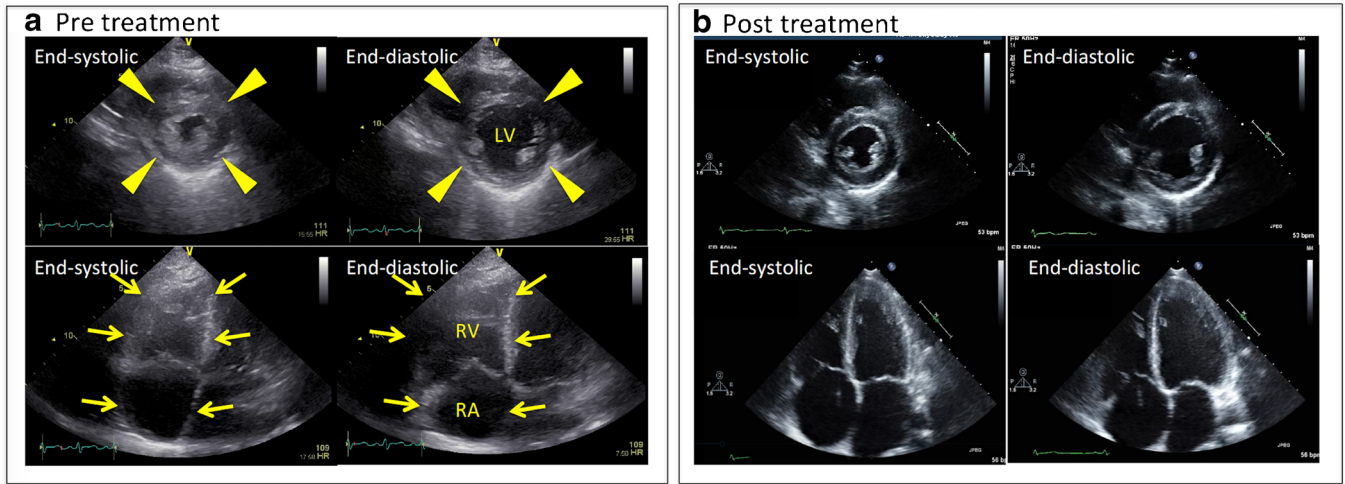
Upper images show parasternal short-axis views and lower images demonstrate echocardiographic apical four-chamber views (end-diastole on the left and end-systole on the right) on arrival (a) and on day 11 after admission (b). On arrival, the left ventricle (LV) was hyperdynamic, with an ejection fraction of 68% (arrowheads). The right atrium (RA) and ventricle (RV) were enlarged (48 mm and 50 mm, respectively; arrows). The hyperdynamic state of the left ventricle and the size of the right ventricle improved to normal after treatment with thiamine and furosemide (b).
